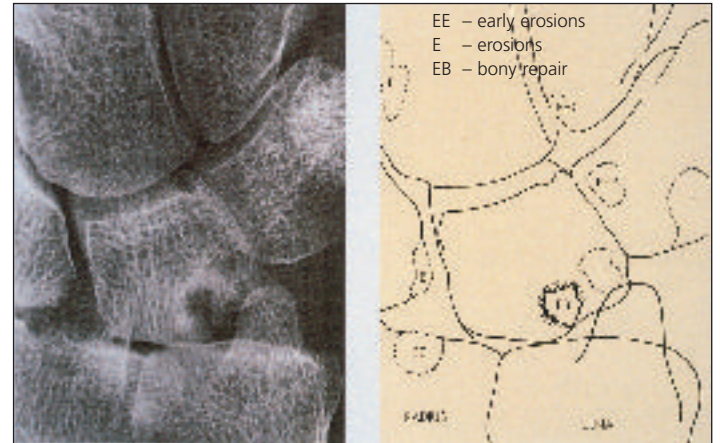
X-ray of the hand in early RA (Courtesy Prof. C Buckland-Wright)
